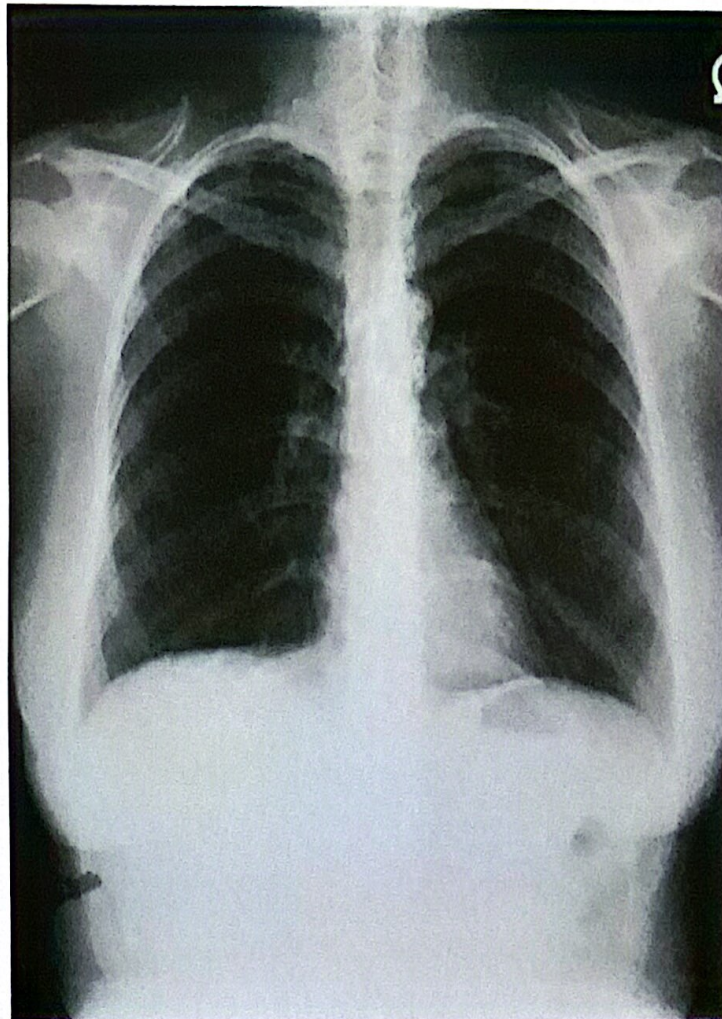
PA projection chest radiograph shows slight rotation of the thorax because the medial ends of the clavicles are not equidistant from the midline. The medial portions of the scapulae are projected over the lateral lung fields, indicating that the patient's shoulders were not sufficiently rolled forward toward the IR.
